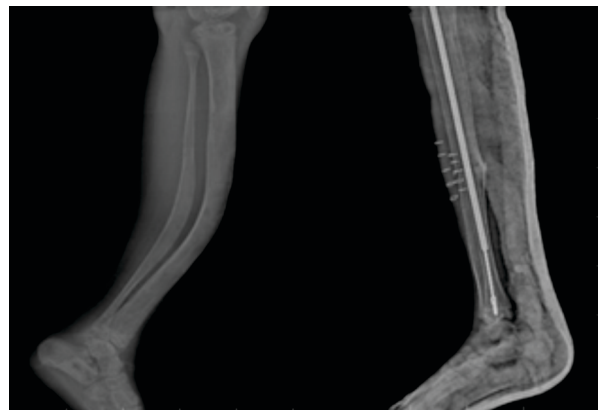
Lateral view showing Preop and postop xray of a 10y old child with OI with anterior bowing of both tibia treated with Osteotomy and telescopic nailing
